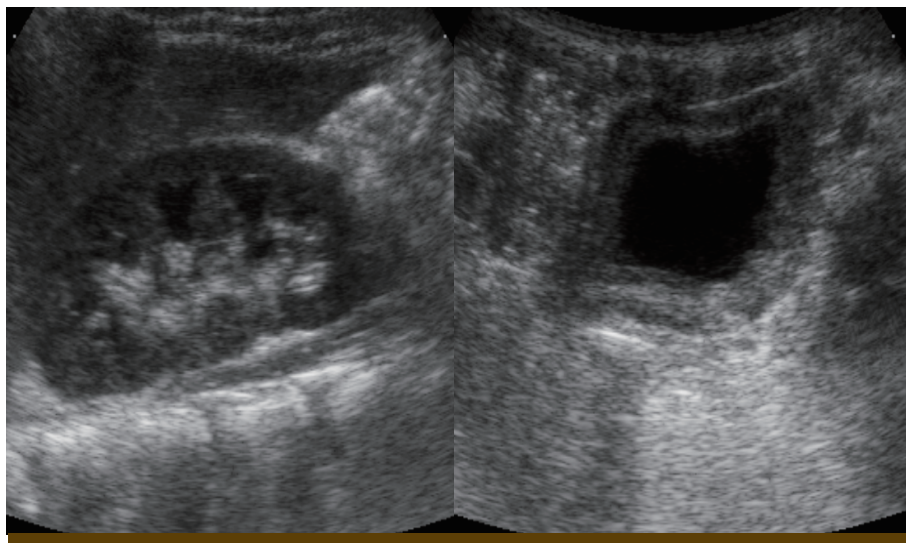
Renal ultrasonography performed 1 week later showed that the thickened bladder wall was improved, but still remained and the improved hydronephrosis was also observed.
